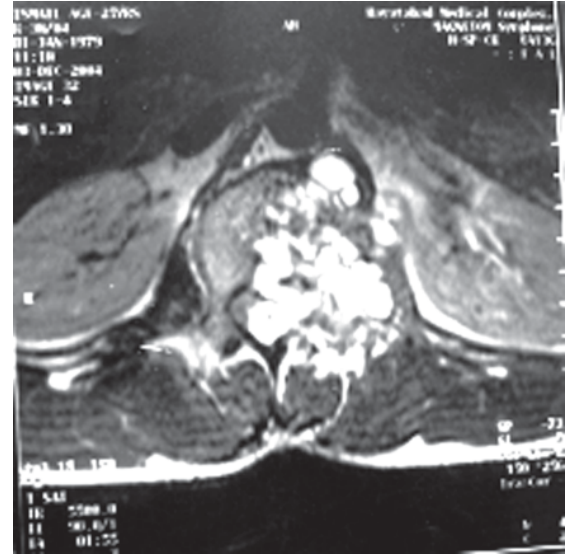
MRI scan showing hyperintense multiple cyst involving vertebral body, pedicle and spinal cord.
